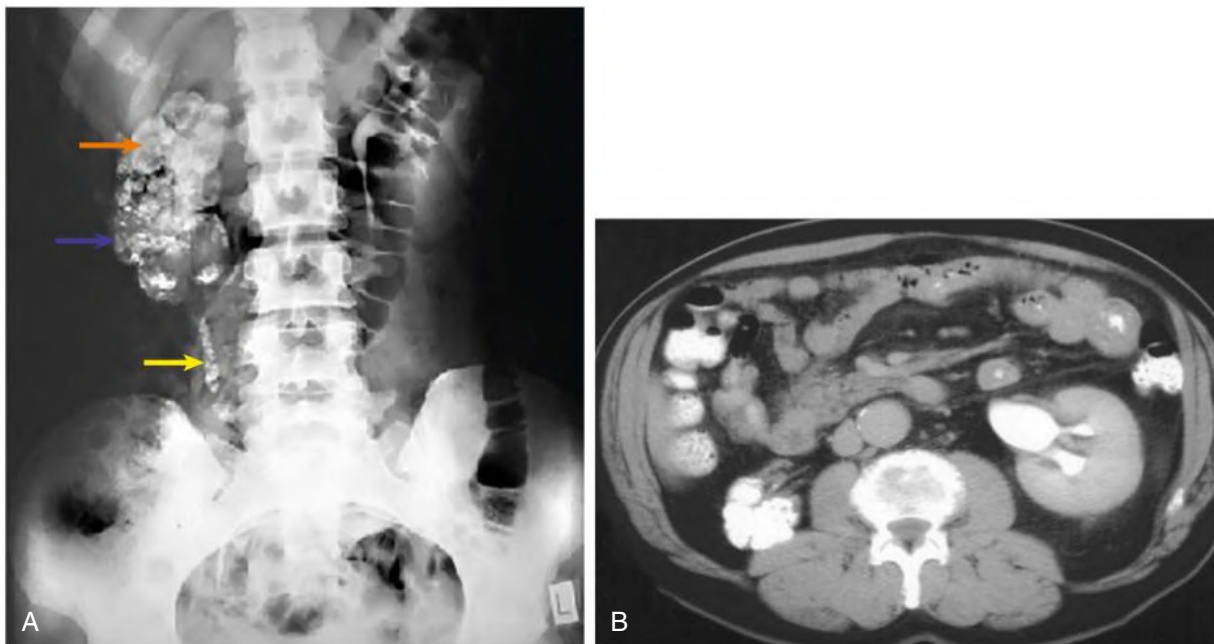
Types of calcification. (A) Curvilinear pattern (*orange arrow*), amorphous and speckled pattern (*blue arrow*), ureteric calcification (*yellow arrow*). (B) Contrast-enhanced computed tomography image showing contracted densely calcified right kidney and normally functioning left side (density on right side was the same before and after contrast).
